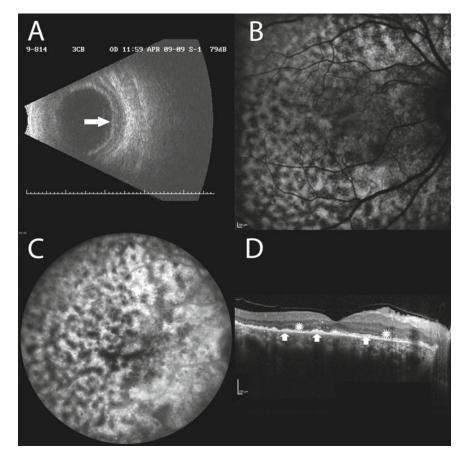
Case of recurrent ciliochoroidal detachment in a patient with positive serology to *Borrelia burgdorferi*. Transverse B-scan ultrasonography (a) directed toward the ciliary body nasally in the right eye, showing extensive, shallow elevation of the ciliary body (*arrow*). Autofluorescence (b) and mid-phase FA (c) images from the same eye showing leopard skin pattern of alternating
